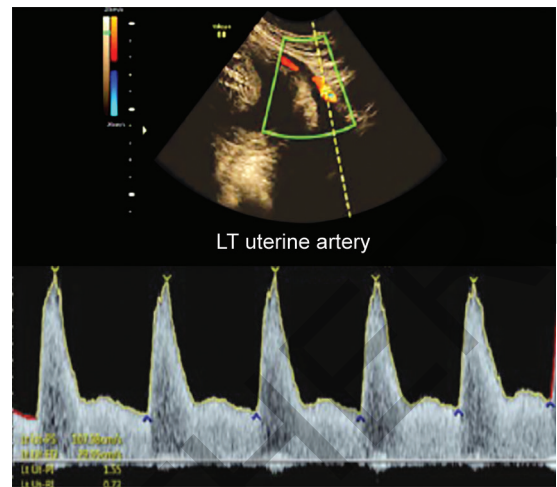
Uterine artery Doppler for screening for PE at 21 weeks (normal finding) (IUGR: intrauterine growth restriction; PE: preeclampsia)
